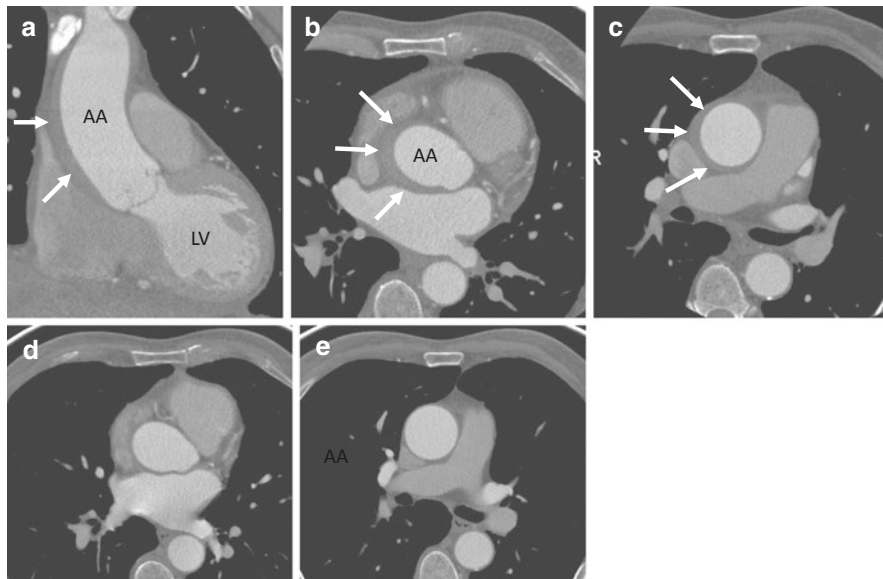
Postcontrast CT images demonstrate an 8 mm thick type A IMH in a 54-year old man with chest pain (a-c) that is found to have resolved at 3 month follow up (d, e) with medical management only. AA Ascending aorta; LV Left ventricle
